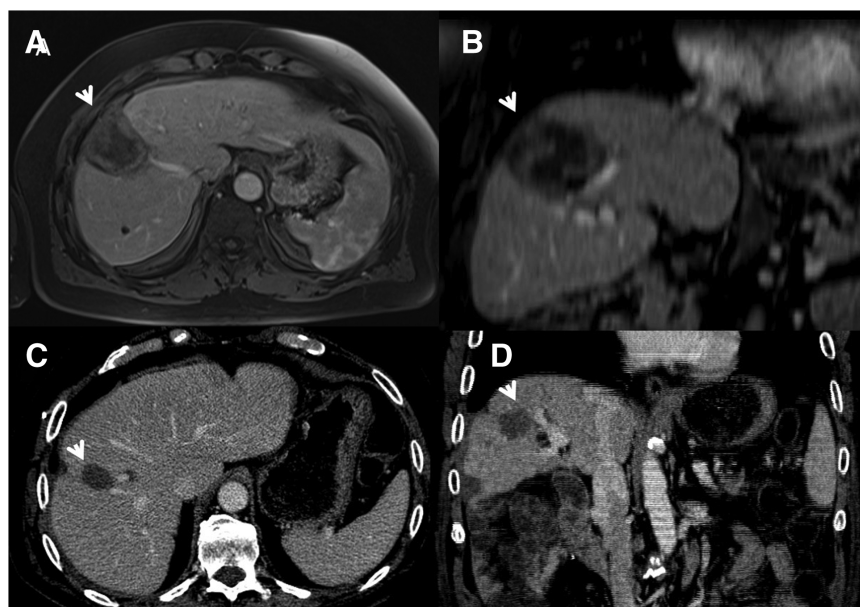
A 51-year-old man with colorectal liver metastasis. Magnetic resonance imaging [(A) VIBE T1-W FS during portal phase of contrast study and (B) Multiplanar reconstruction in coronal plane] and multidetector CT [(C) portal phase of contrast study on axial plane and (D) MPR in coronal plane] studies show lesion without enhancement, with regular enhancement of portal branch near to the treated area. The time between the MDCT examination and MR scan is 7–10 days.
